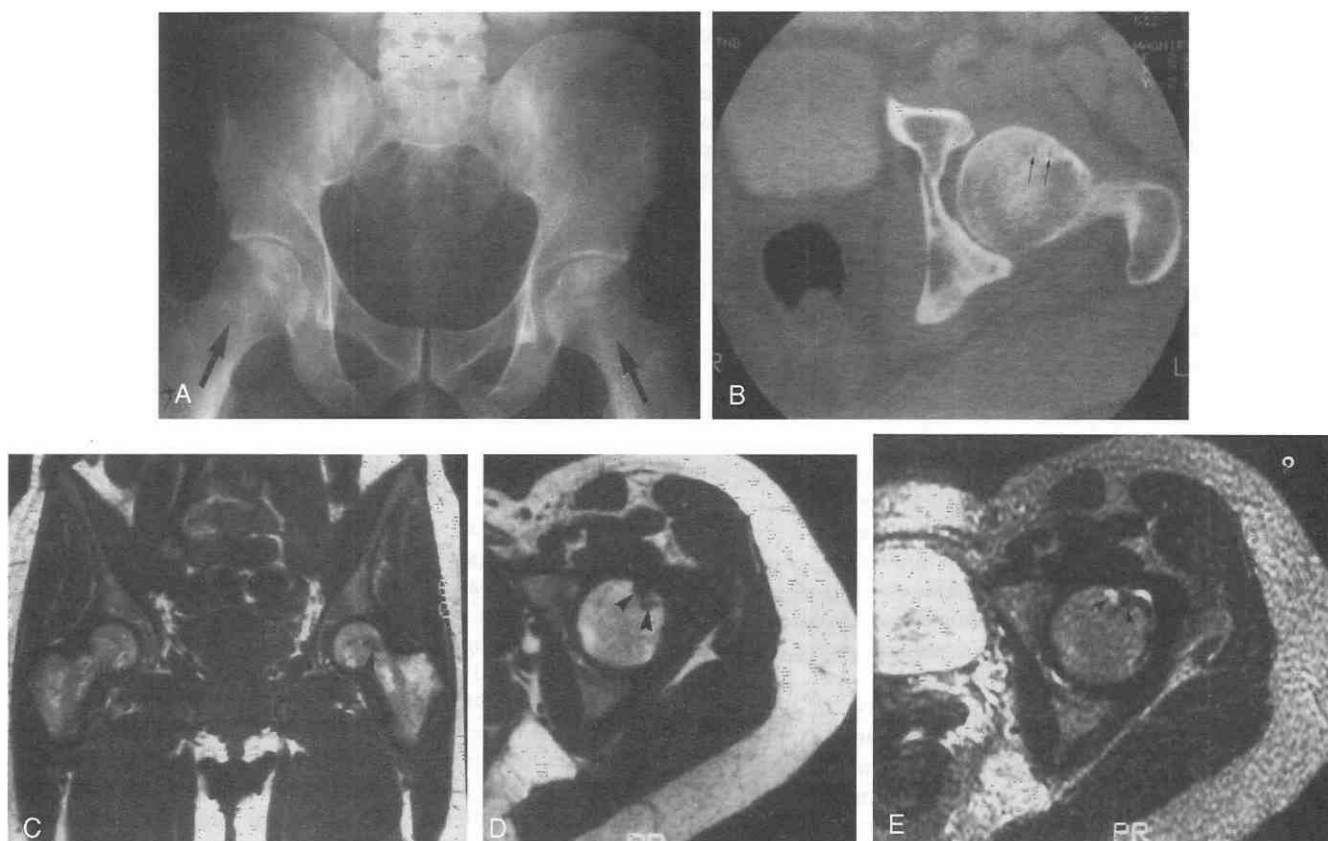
Conversion defects in asymptomatic patients. *A*, Pelvic radiograph shows large conversion defects bilaterally seen as subcapital lucencies with surrounding sclerosis (*large arrows*). *B*, CT scan shows a small herniation pit in the anterior subchondral region (*small arrows*) with vertical extension toward the cortex. *C* and *D* T1-weighted MR images in the coronal (*C*) and axial (*D*) planes reveal herniation pits as focal areas of marrow replacement (*large arrowheads*). This region reveals a channel-like appearance that extends toward the anterior cortex in the axial plane. *E*, Axial T2-weighted MR image reveals heterogeneous signal intensity in the conversion defect (*small arrowheads*), consistent with both fluid and fibrocollagenous tissue.
